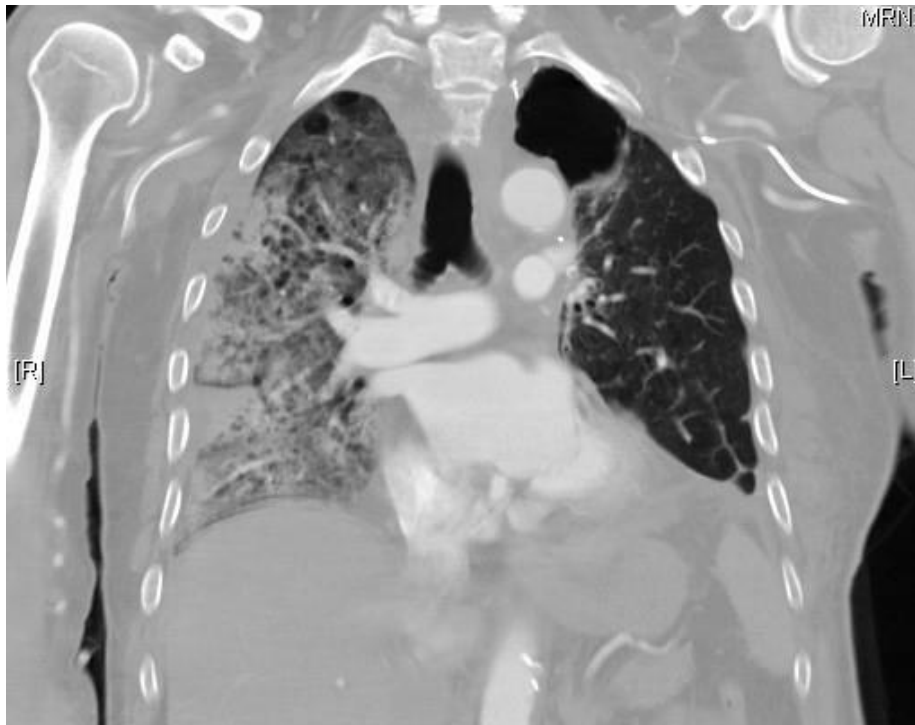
Coronal section of CTA chest showing extensive patchy consolidation, right worse than left. Also noted is the absence of the left upper lobe.
